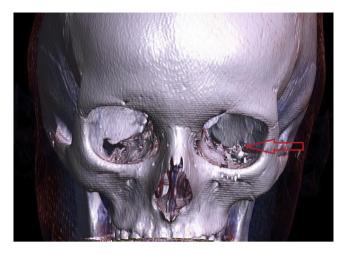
Same patient; CT scan, 3-D reconstruction. Intraorbital air gun pellet (arrow).
